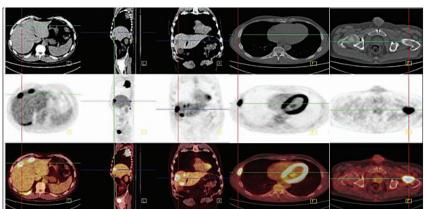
A 41 years old man with lungadenocarcinoma, stage T3N2M1c, undervent bullectomy. Coronal, axial and sagital section. This is pretherapeutic PET/CT scan. The MIP image shows multiple hypermetabolic foci in liver and sceleton (located in right scapula, 3th, 4th and 12th rib on the right, 7h rib on the left, both iliac bones, left femoral dyaphisis).
